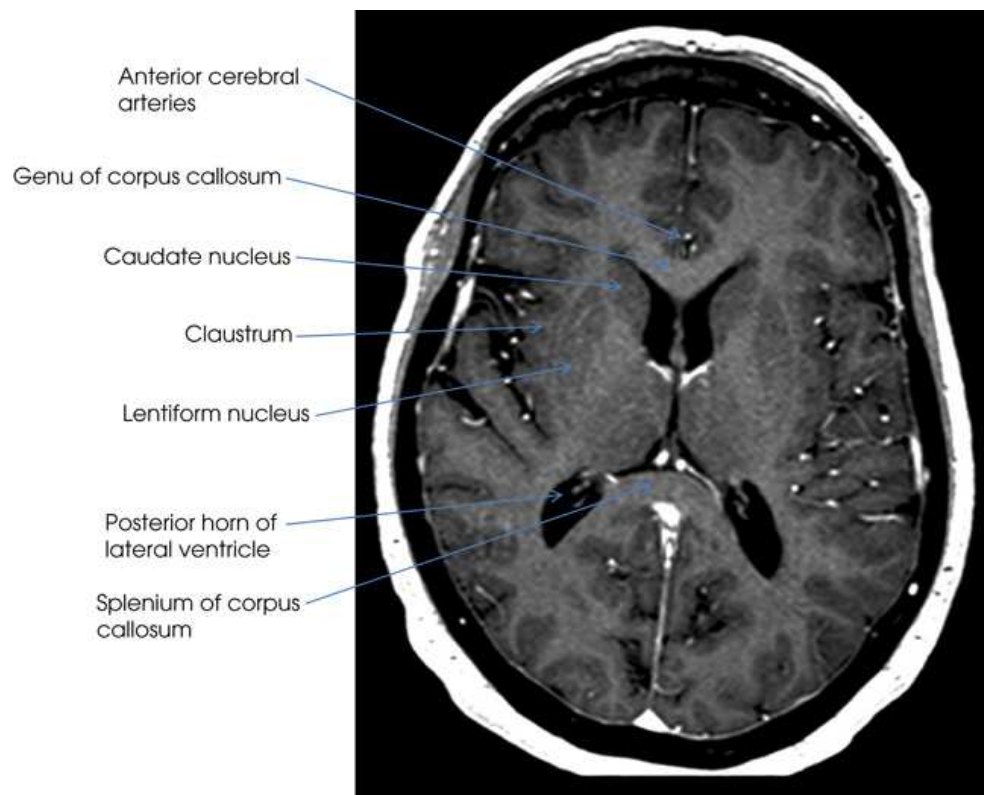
MRI representing anatomic structures located at level C in Fig. 24.5B.
